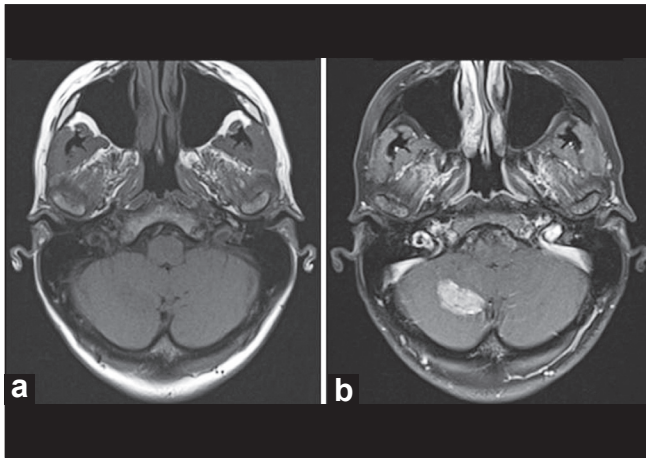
(a) Magnetic resonance imaging demonstrating the tumor in the right cerebellar hemisphere as a hypointense lesion in a T1-weighted image (b) and as an enhancing lesion in a gadolinium T1-weighted image
